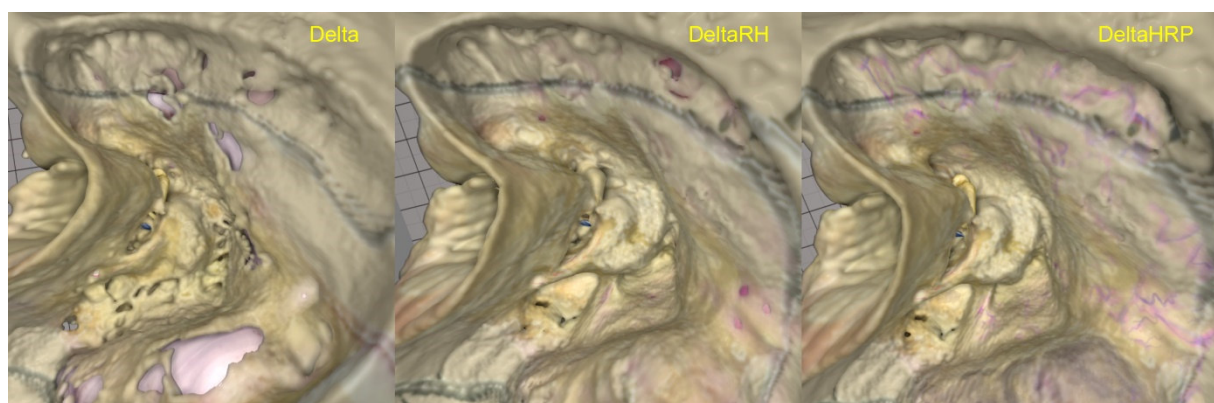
Examples of how bony defects appear in the differently processed datasets of Delta during a virtual drilling of an anatomical mastoidectomy. Left: The clinical CBCT dataset has large artefacts seen as dehiscences at dura and sinus. Middle: The high-resolution CBCT dataset has smaller dehiscence artefacts but the ossicles are embedded in bone. Right: The manually post-processed high-resolution dataset has no bone artefacts.
